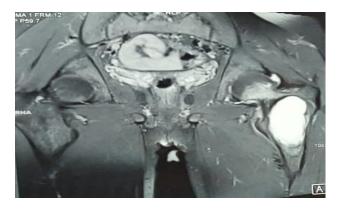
T2 weighted coronal MRI image showing hyperintense single cavity in left proximal femur.
